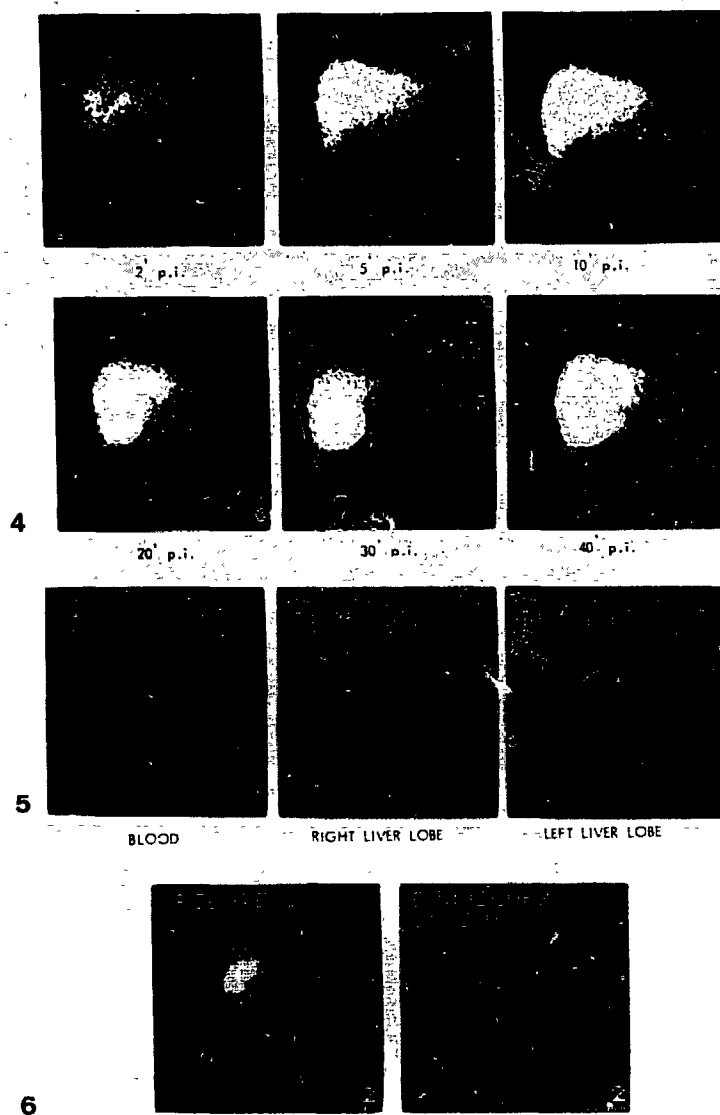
4-6 Cholescintigraphy in a patient with chronic active hepatitis.
